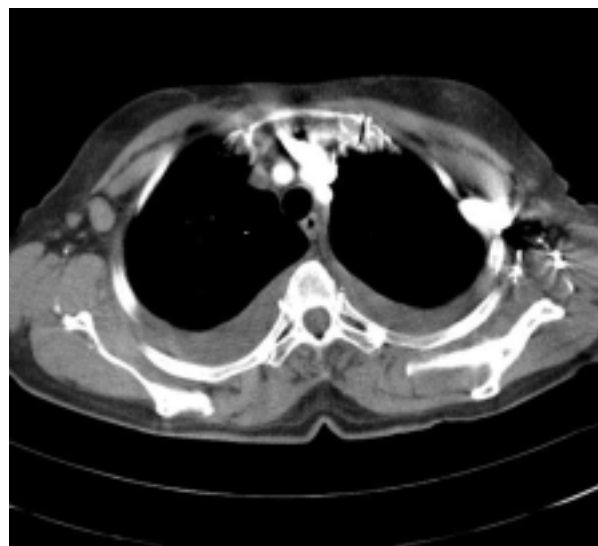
Patient's chest CT scanning revealing enlarged axillary lymph nodes
